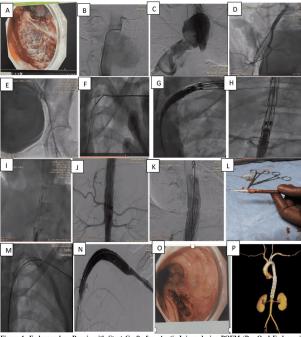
Endovascular Repair with Stent Graft for Aortic Injury during POEM (Per Oral Endoscopic Myotomy) Procedure. A) Endoscopic picture showing profuse bleeding into the oesophagus from the sub-mucosal tunnel. B.C.) Fluoroscopic images with leaking of contrast from descending aorta to ecsophagus suggesting aortic rupture. D.E.) Perfootund Spasm involving right and left femoral arteries respectively. P. Left Subclavian artery puncture for access, G.H.) 26mmX26mm, 100cm Valiant thoracic Stent graft inserted through Left Subclavian access and deployment position checked just above the level of origin of coeliac artery respectively. I) Release of stent graft, K.J. Final aortograms with no leak of contrast from aorta to esosphagus. L.) Avulsion of subclavian artery along with perclose-proglide sutures over the Capitiva delivery system, M) Subclavian artery rupture sealed with two Fluency plus Vascular Stent Grafts(10X60cm & 8X100cm, proximal and distal respectively), N) Subclavian angiogram showed good sealing with no leak. O) Endoscopic image depicting preserved mucosal flap integrity with minimal clots, P) CT images post procedure depicting aortic stent graft with no Endo-leak and patent subclavian stents.
